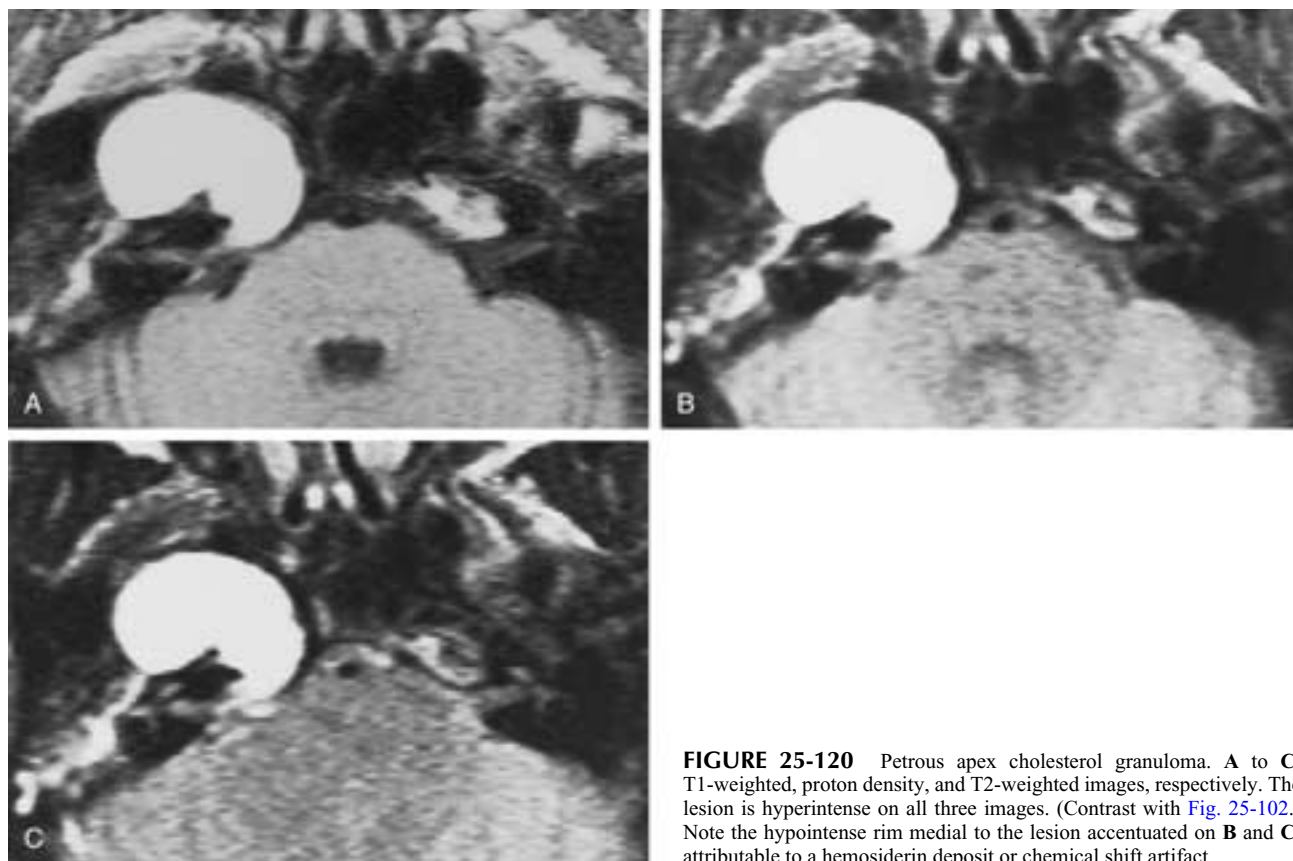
Petrous apex cholesterol granuloma. A to C, T1-weighted, proton density, and T2-weighted images, respectively. The lesion is hyperintense on all three images. (Contrast with Fig. 25-102.) Note the hypointense rim medial to the lesion accentuated on B and C, attributable to a hemosiderin deposit or chemical shift artifact.
